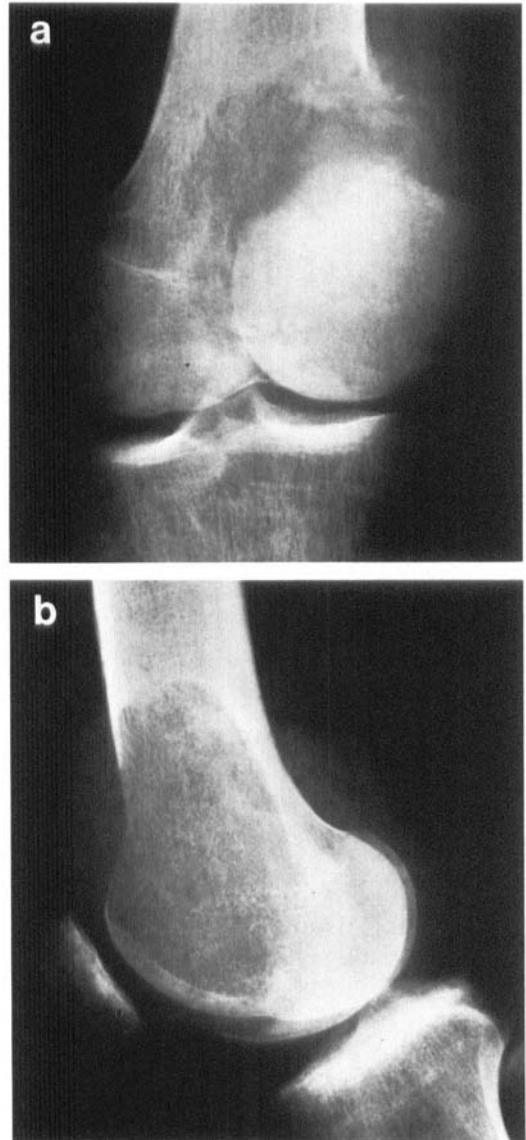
a and b. Preoperative AP (a) and lateral (b) radiographs of a typical osteolytic epiphyseal giant cell tumor in a 28-year-old woman with a pathological fracture (Case 4).
